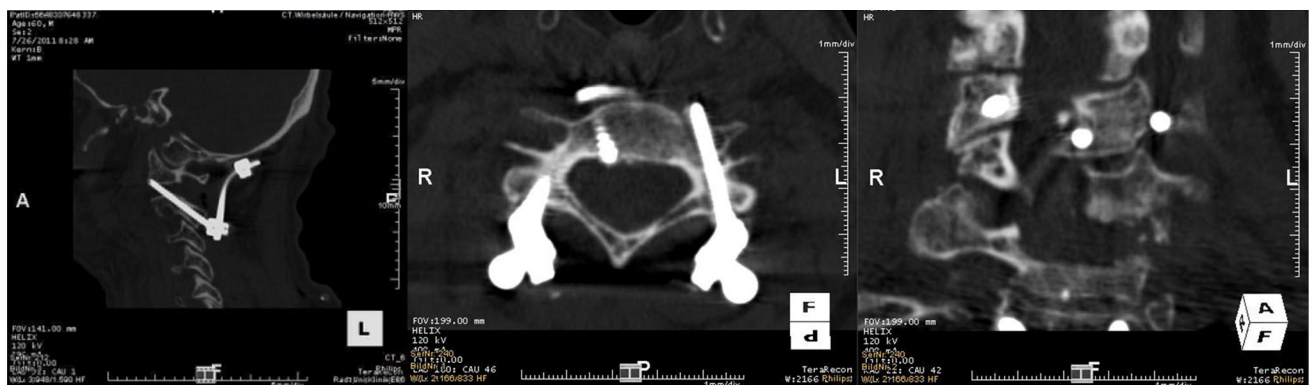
Postoperative CT scan in sagittal, coronal, and axial planes, grade 5 in modified Gertzbein and Robbins classification
